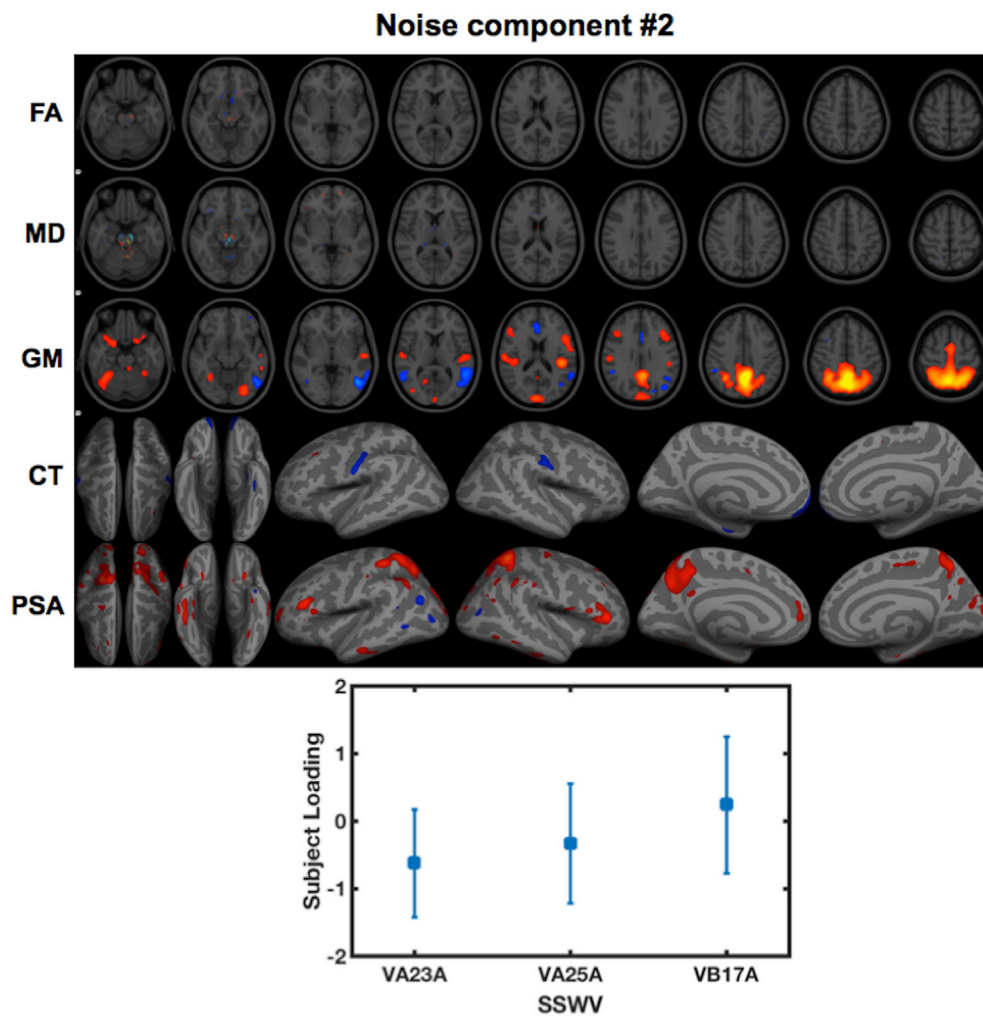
A second multimodal noise component identified from LICA. Loadings for this component were only associated with SSWV ($p = 2.15 \times 10^{-4}$). The spatial pattern shows region-specific effects in FA, MD, GM, CT and PSA. The spatial maps were thresholded at $Z = 2.3$.
